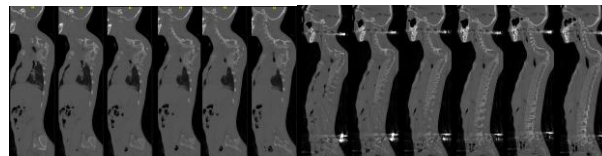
Comparison of sagittal view of pre- and post-traction CT
